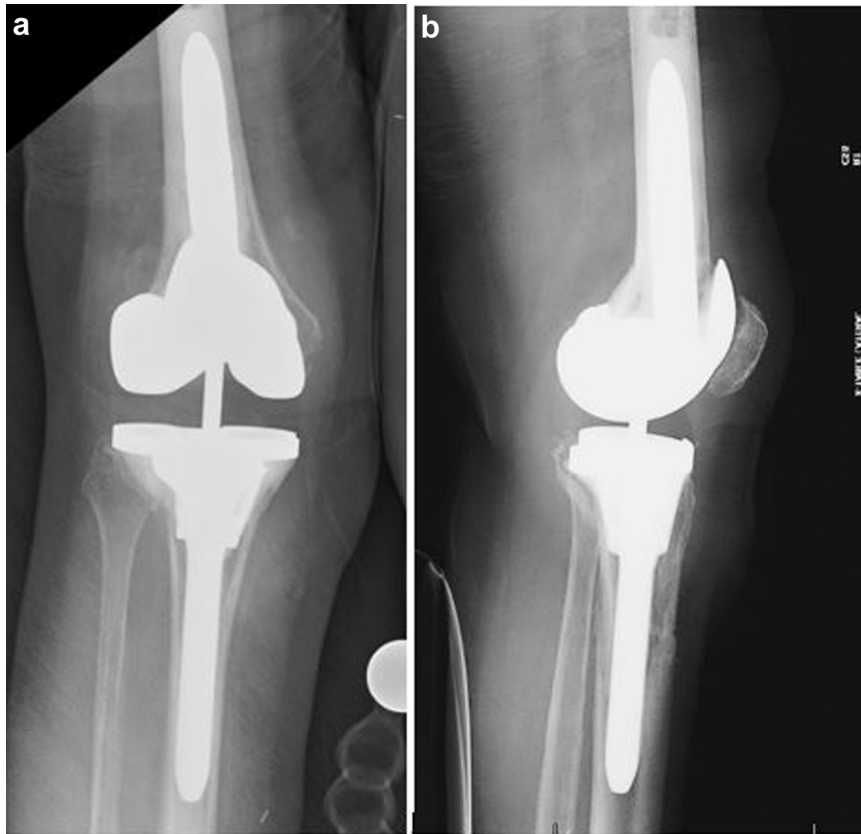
Post-reimplant radiographs. Anteroposterior (a) and lateral (b) radiographs after stage 2 revision TKA.
